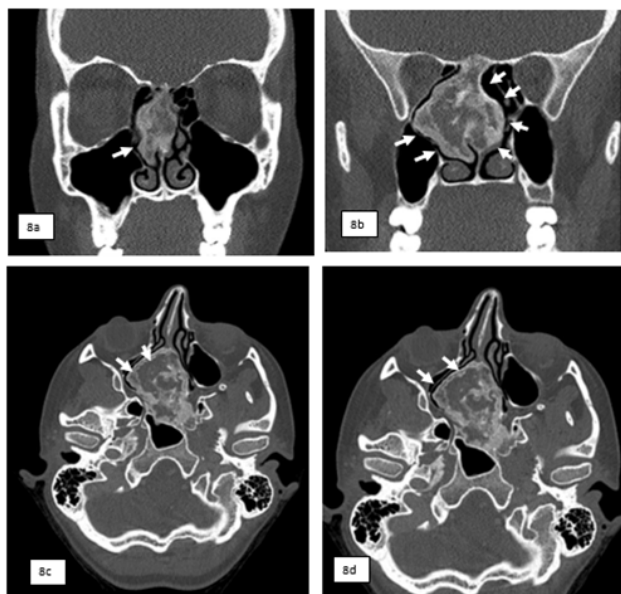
Sinus CT scan coronal and axial cuts showing a bony tumour implanted on the skull base, obstructing the nasal cavity (white arrows).
